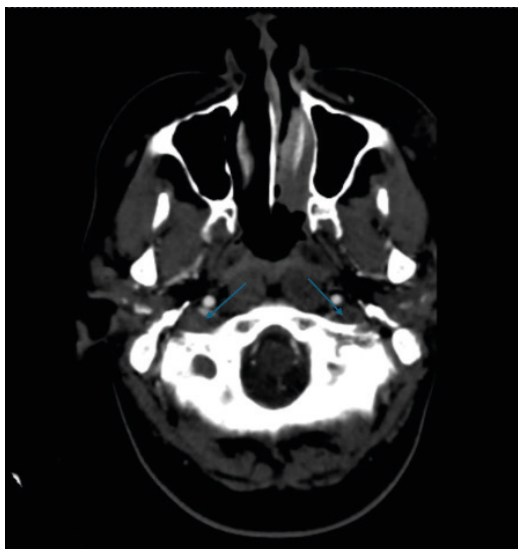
Computed tomography angiography of the skull showing: failure of the right and left jugular veins to fill in their distal portions.
